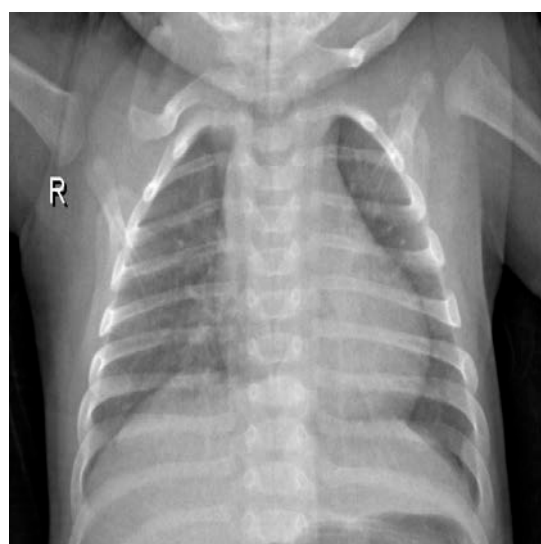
X-ray image of healthy patient.
